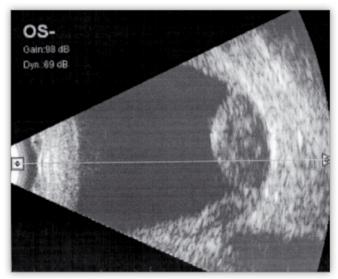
Choroidal detachment on ultrasound exam. Ryc. 4. Odłączenie naczyniówki w obrazie USG.
